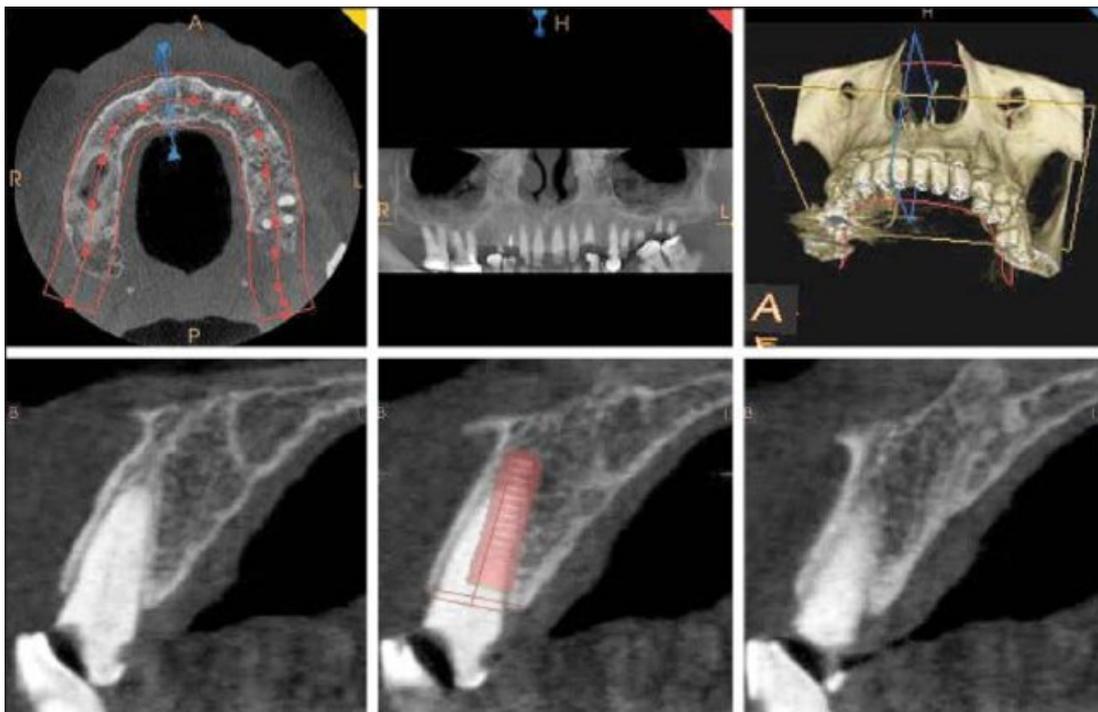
Cone beam computed tomography planning in the maxilla [68].
